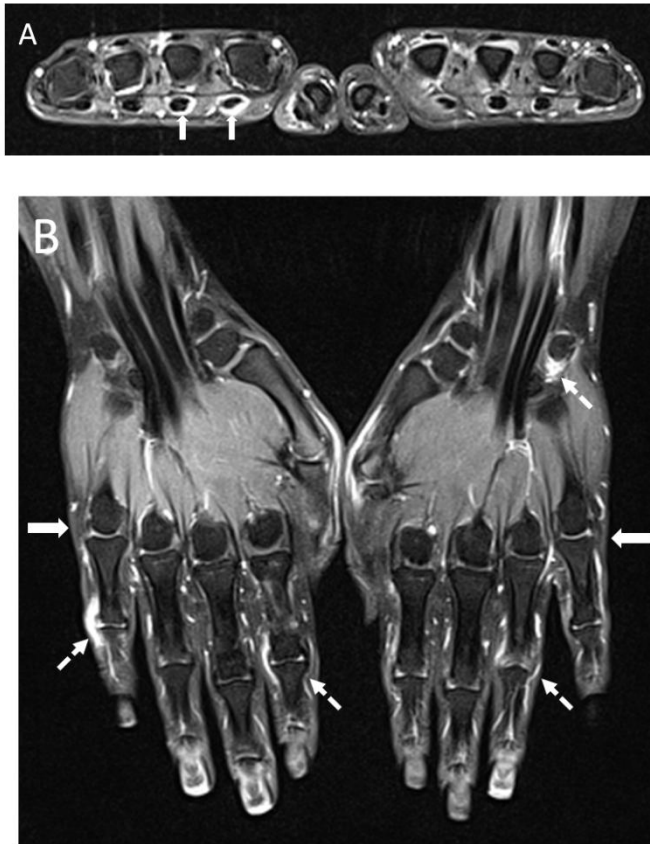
Bilateral magnetic resonance imaging (MRI) of the hand and wrist of a 33-year-old woman with early inflammatory arthritis with a disease duration of 3 months; she did not fulfil the criteria for a specific diagnosis at the time of MRI examination (with a calculated score at presentation of 5 according to the 2010 rheumatoid arthritis (RA) classification criteria of the American College of Rheumatology/European League against Rheumatism), but did fulfil both the 1987 ACR and 2010 RA classification criteria for RA at the 12-month clinical follow-up. (A) Axial T1 fat-sat sequence after intravenous contrast administration showing grade 2 (≥ 2 and < 5 mm synovial proliferation with enhancement) tenosynovitis of the flexor tendons of the second and third digits on the right (arrows). (B) Coronal T1 fat-sat sequence after intravenous contrast administration at the metacarpophalangeal joint level (arrows), demonstrating absence of metacarpophalangeal joint synovitis. Bilateral interphalangeal joint synovitis and left radiocarpal joint synovitis (pisotriquetral synovial recess) is noted (dashed arrows).
